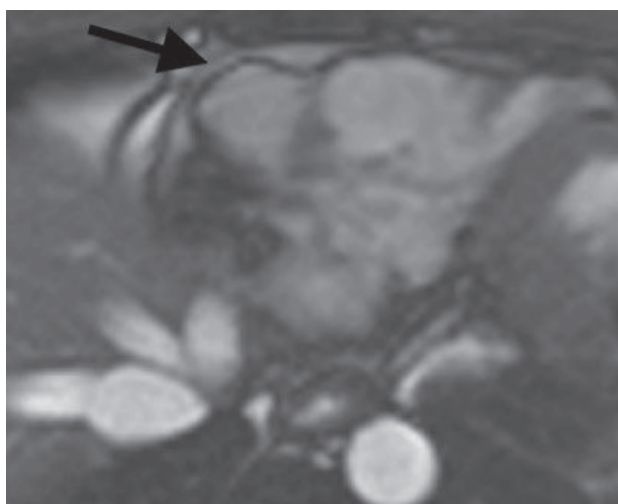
Axial slice of the right ventricle on cardiac MRI from a patient with ARVC/D. (Black arrow points to areas of regional dyskinesia and aneurysm formation on the RV free wall.)
